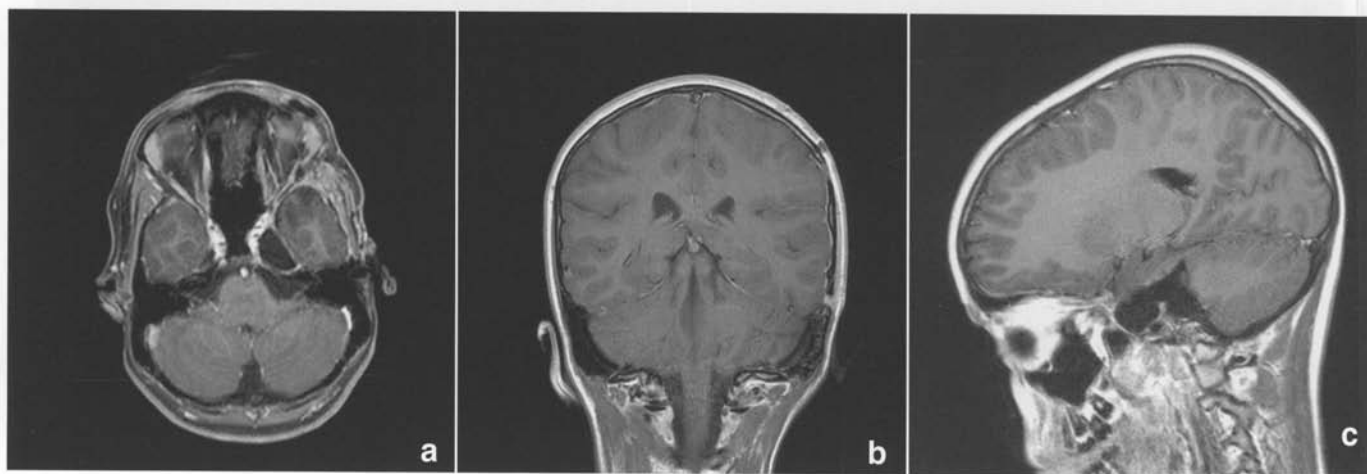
Post operative a) axial, b) coronal, c) sagittal MRI with gadolinium showing complete resection of tumour.
